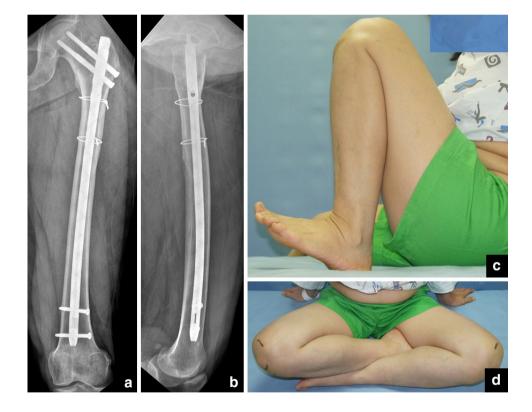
The radiograph after 6 months demonstrated healing of the fracture (a, b) with an excellent function (c, d)
